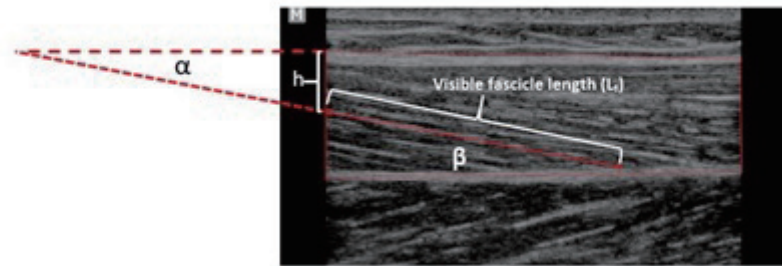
(Color online) Ultrasound images of LG muscle of representative elderly participant. Muscle lengths of the visible FL (L_1) and PA (β) were measured. The thin line represents superficial and deep aponeuroses. The PA (β) is the angle between FL and deep aponeuroses.
